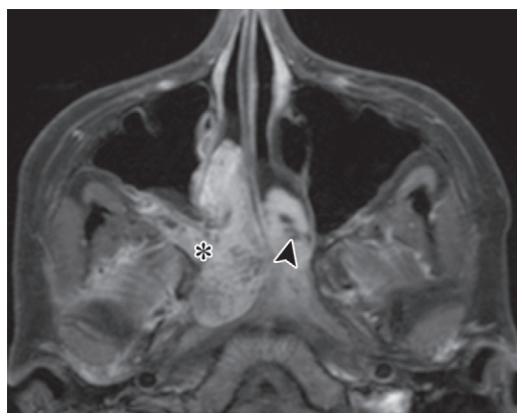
Juvenile nasopharyngeal angiofibroma in a 14-year-old adolescent boy with epistaxis and congestion. Axial contrast-enhanced T1W FS MR image shows an avidly enhancing nasopharyngeal mass centered at the sphenopalatine foramen (*), with internal flow voids (arrowhead).
